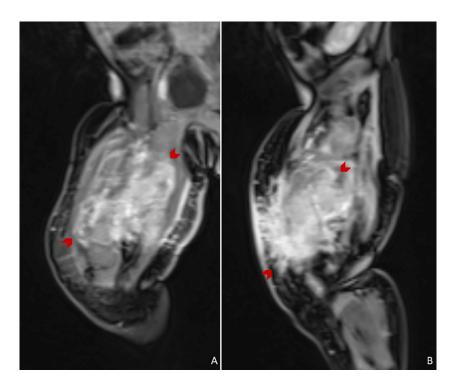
Magnetic resonance imaging of the right thigh. Coronal (A) and sagittal (B) postcontrast T1-weighted images with fat suppression demonstrate the infiltrative and locally invasive nature of the lesion. The large soft tissue mass involves all muscle compartments of the thigh and shows heterogeneous enhancement after contrast administration (arrowheads, A and B).
